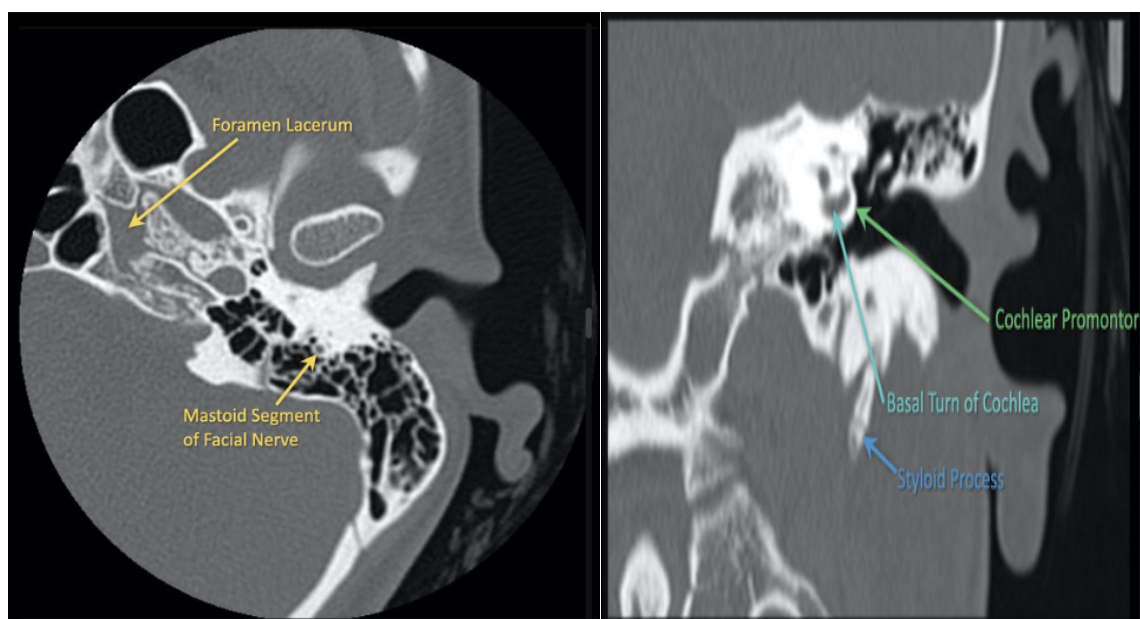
HRCT showing Normal temporal bone
